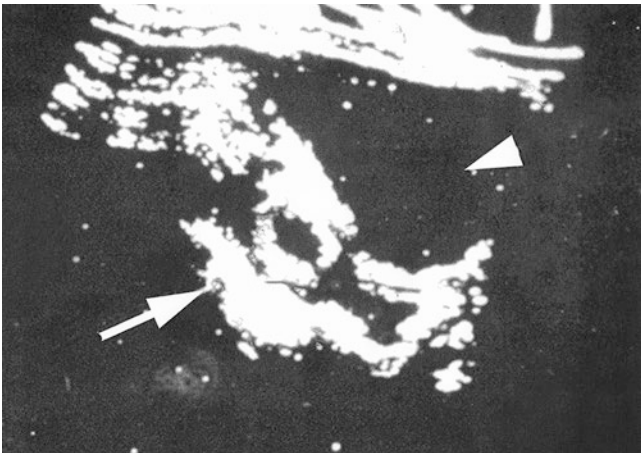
1963 ultrasound performed by Prof. Ian Donald, showing a foetus in utero (arrow) using the urinary bladder (arrowhead) as an acoustic window
